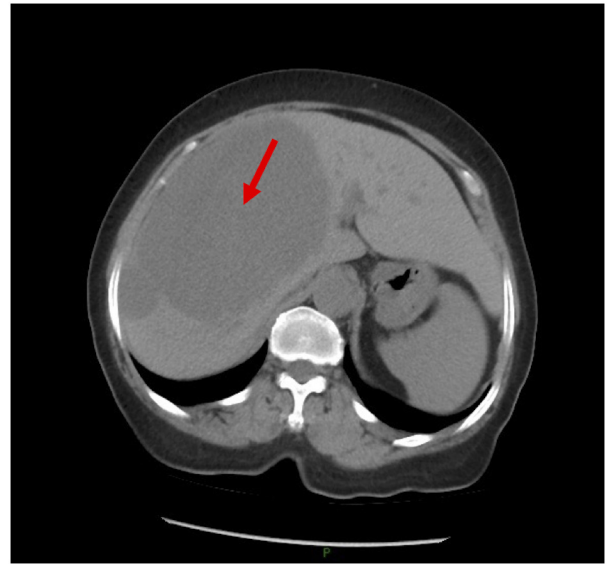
Abdominal CT image showing multiple liver lesions.
